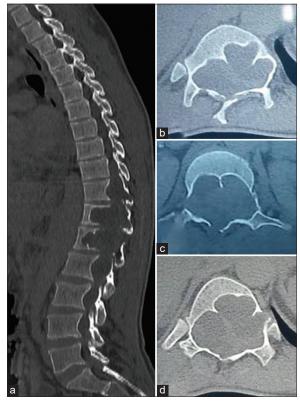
Sagittal (a) and axial (b-d) computed tomography scan images showing extensive posterior scalloping of T12 and L1 vertebral bodies, and erosion of laminae and pedicles.
